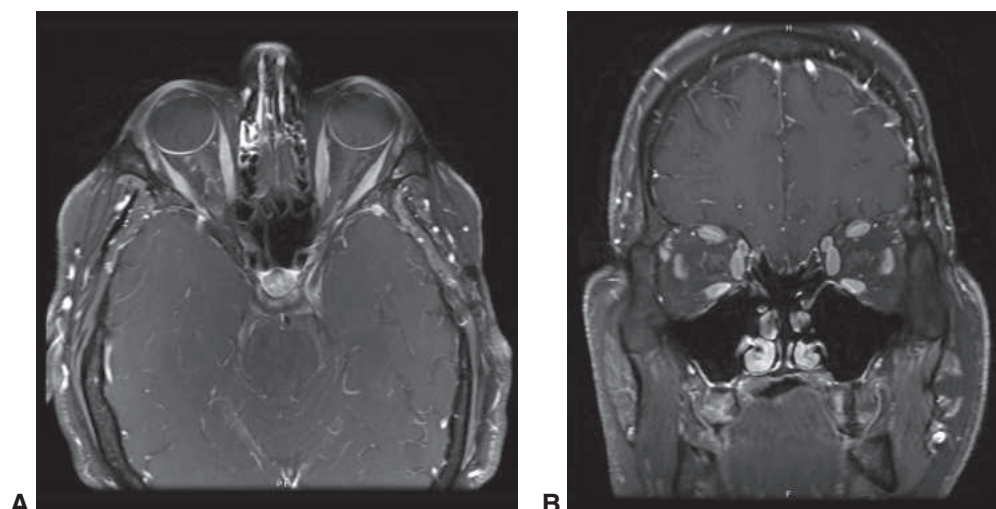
Gadolinium-enhanced T1-weighted magnetic resonance imaging of the orbit, with fat suppression; normal anatomy is demonstrated. A, Axial view. B, Coronal view. (Courtesy of M. Reza Vagefi, MD.)
